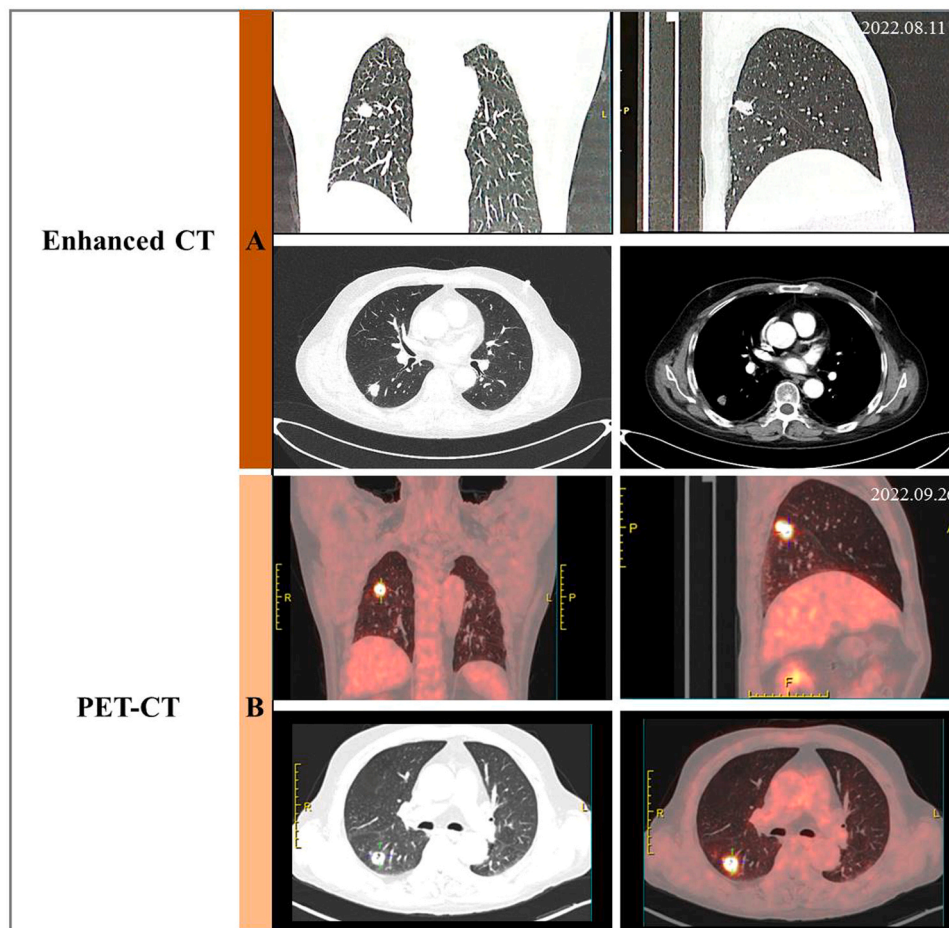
Contrast-enhanced CT and PET-CT findings of the pulmonary cryptococcosis in our MN patient under long-term tacrolimus regimen. A (the dark brown bar): contrast-enhanced CT showed the isolated subpleural solitary nodule in the dorsal segment of right lower lobe. Spiculation, vacuole and pleural indentation were also visible. B (the brown bar): PET-CT showed accumulation of the ^{18}F FDG in the above said nodule with a maximum standard uptake value of approximately 12.2 and diameter of 1.7 cm. The lesion appeared to be in a shallow lobular shape, with eccentric and irregular small vacuole inside. Adjacent interlobular pleura was pulled and displaced.
